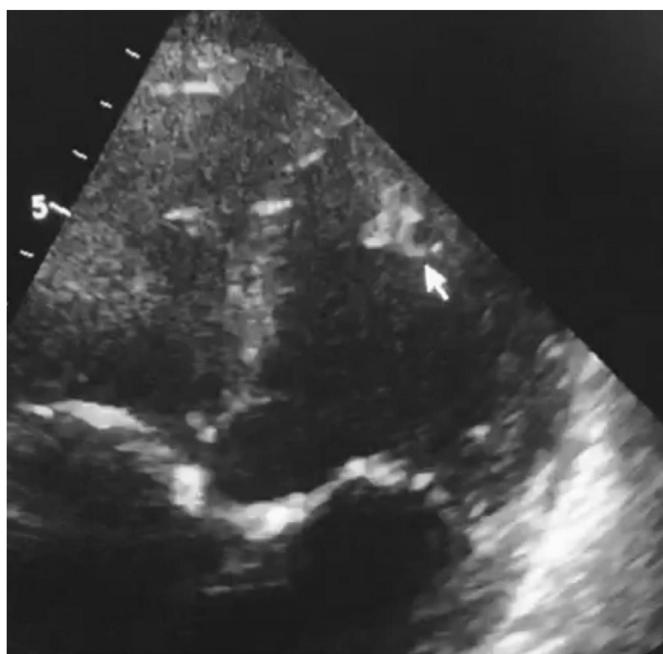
Transthoracic echocardiography shows a voluminous left ventricular thrombus (arrow).
